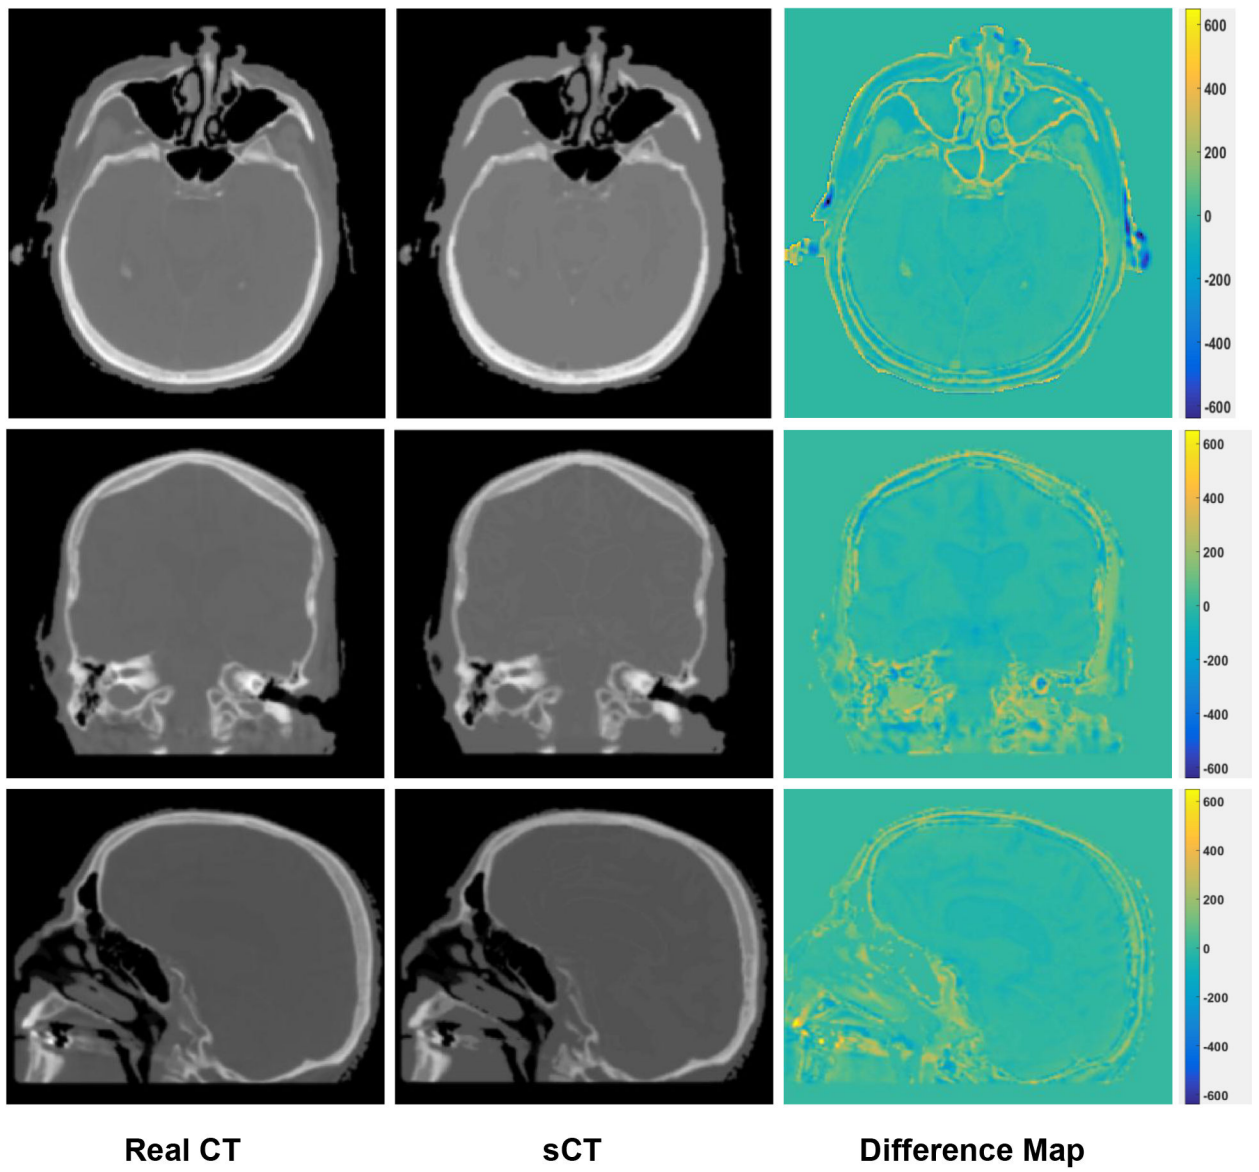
Axial (first row), coronal (second row) and sagittal (third row) slices of real CT, sCT, and their difference map for a typical patient (number 12).
